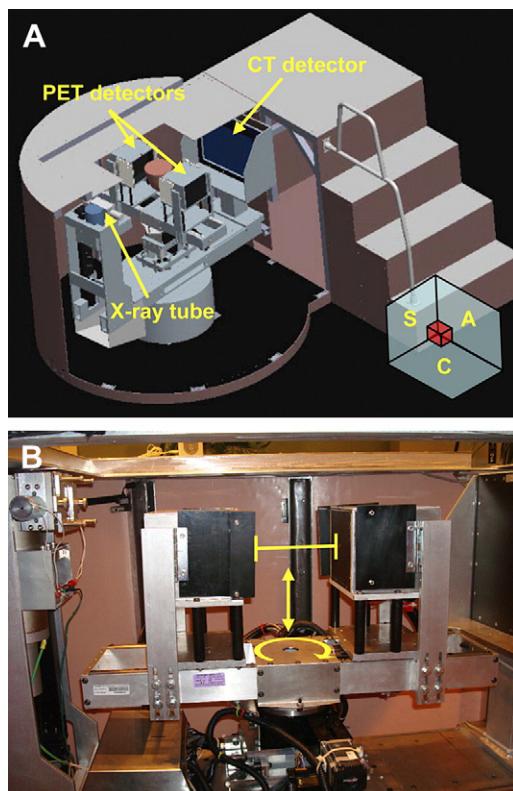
(A) The dedicated breast PET/CT. The object between the PET detectors shows the approximate position of the patient's breast during scanning. Orientation of positioned patient's coronal (C), sagittal (S), and axial plane (A) are shown in the bottom-right-hand corner. (B) PET gantry allows for control of detector height (vertical arrow), separation distance (horizontal line with end markers), and rotation (curved arrow). (Reprinted from Bowen SL, Wu Y, Chaudhari AJ, et al. Initial characterization of a dedicated breast PET/CT scanner during human imaging. J Nucl Med 2009;50:1402; with permission.)
